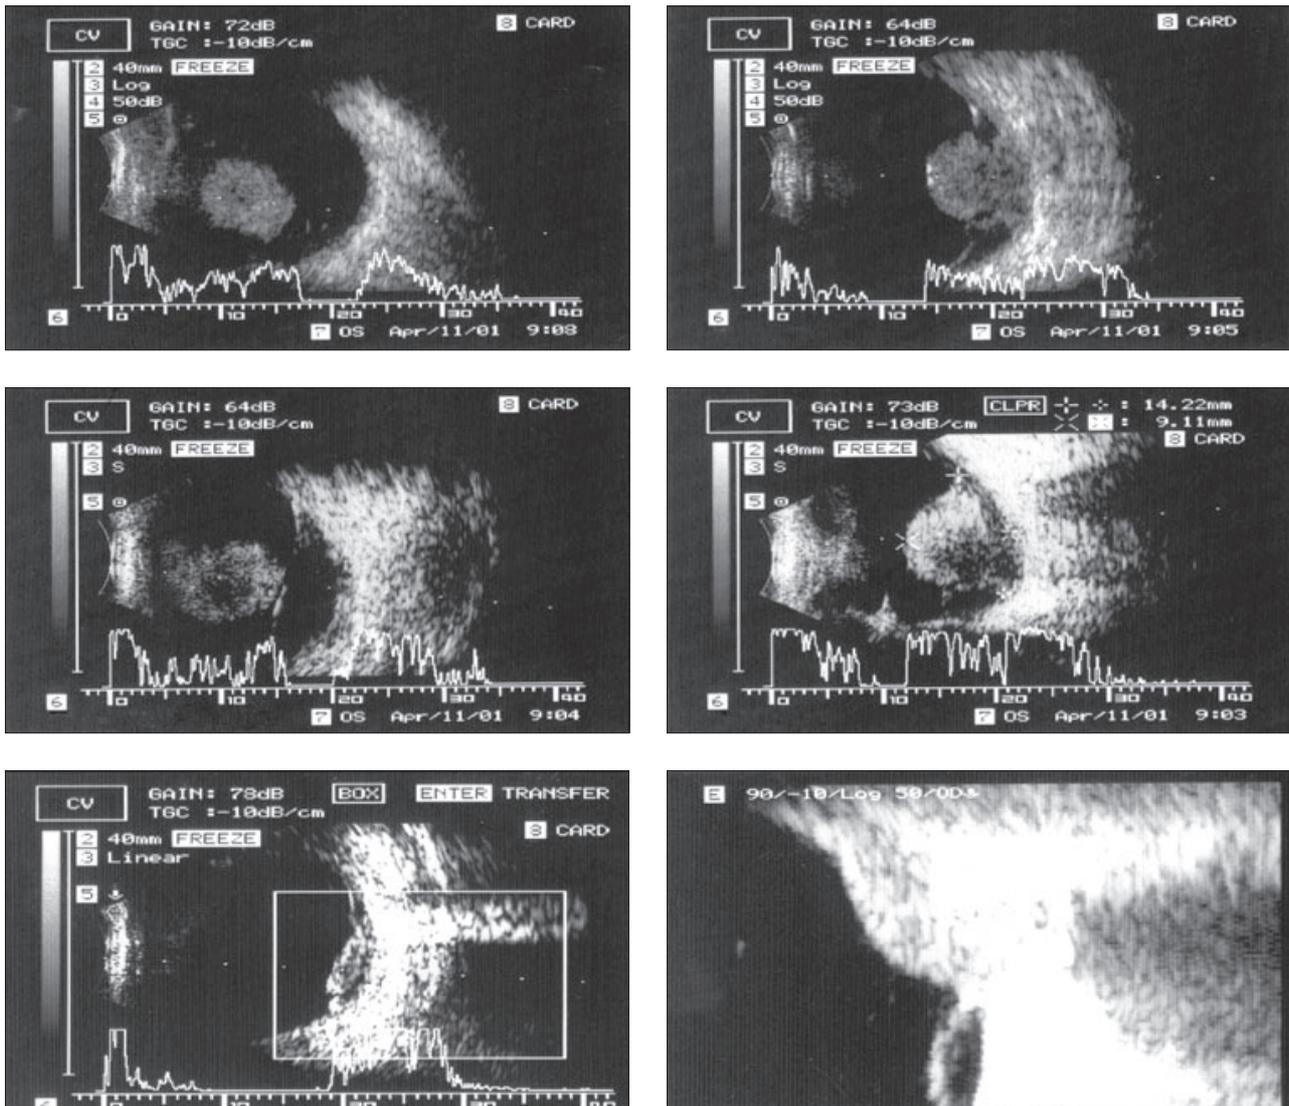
Ultrasound examination in A, B mode is important (size, localization of the tumor, secondary retinal detachment, exsudative retinal detachment)
